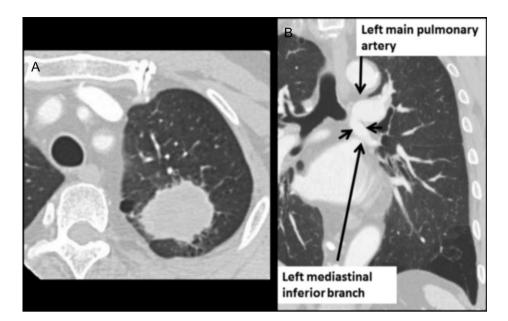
(A) Chest CT shows lung mass in the left upper lobe. (B) Chest contrast-enhanced CT shows the mediastinal anomalous inferior lobar branch.
